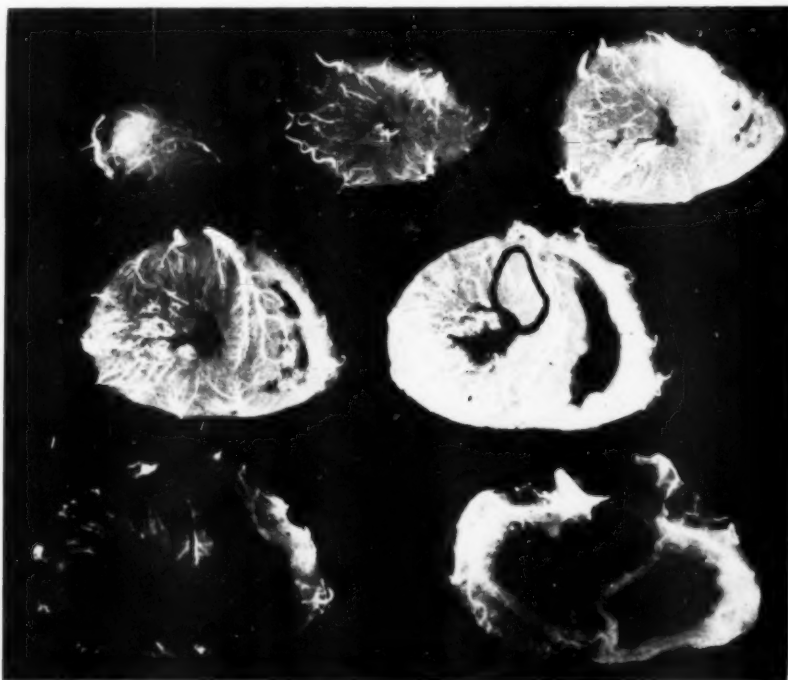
Roentgenogram of the heart of Case 5, showing high anteroseptal infarct outlined in black.
